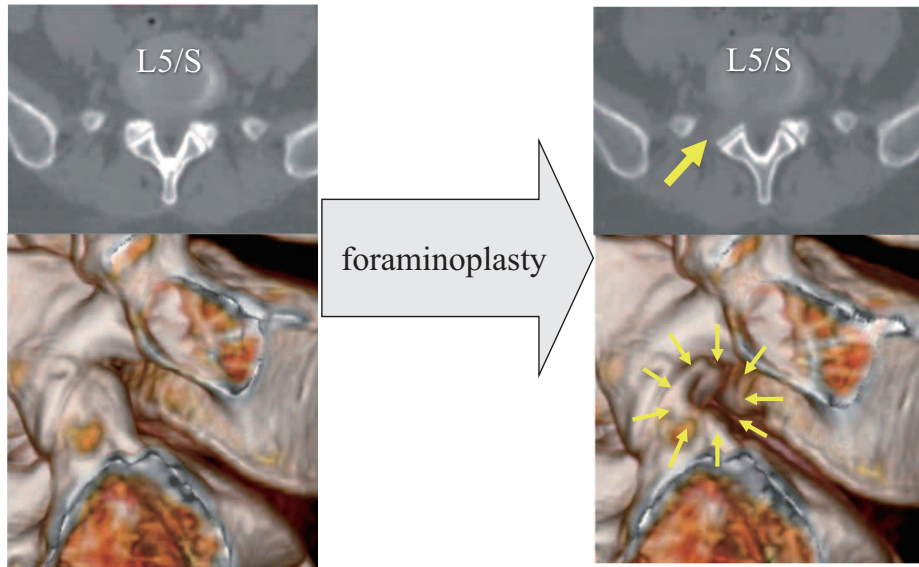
Preoperative and postoperative CT images of an intracanalicular HNP at L5-S1. Due to a high iliac crest, it was difficult to access the L5-S1 disc space without foraminoplasty (left panel). However, after foraminoplasty, the HNP at L5-S1 could be removed (right panel). CT scans show the area of foraminoplasty (arrows).
